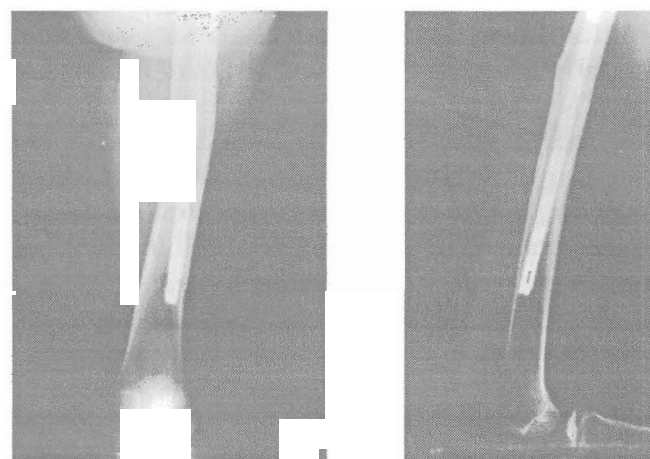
Radiographs of the femur of a 25-year-old patient show fracture healed in varus, (a) anterior-posterior, (b) lateral views.
